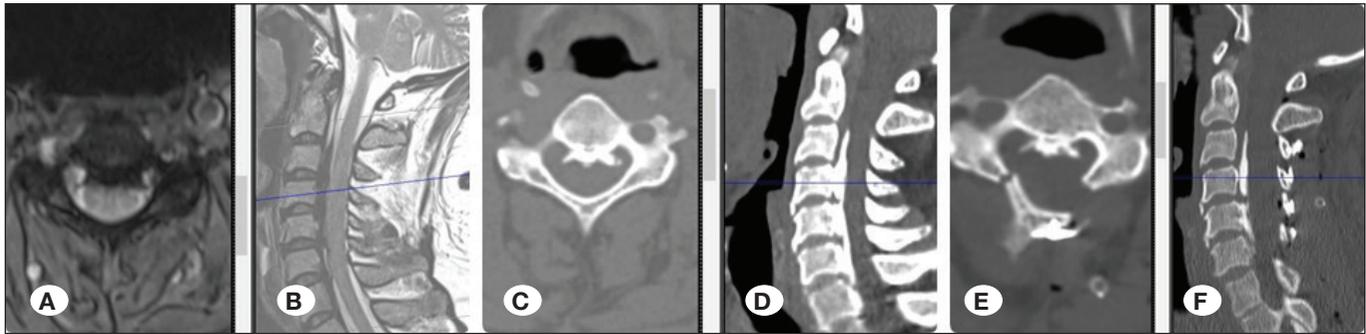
A, B) Preoperative cervical axial-sagittal T2-weighted MRI OPLL. C, D) Preoperative cervical axial-sagittal CT OPLL. E, F) Postoperative cervical axial-sagittal CT OPLL.
